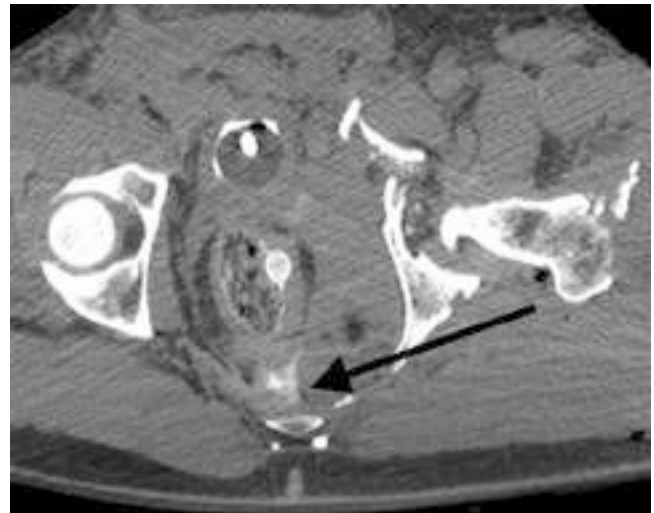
Computed tomography showing rectal injury with contrast extravasation from a severe pelvic fracture.
